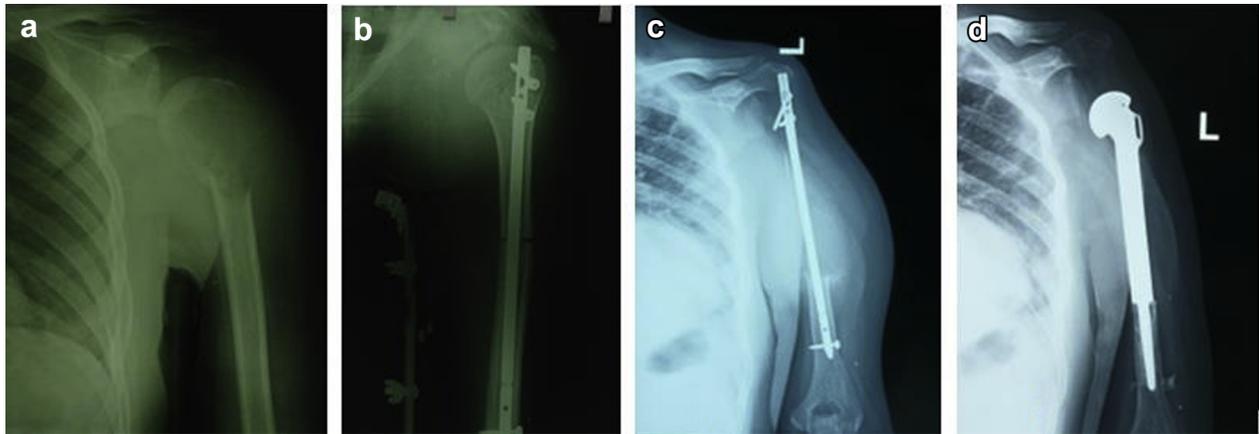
Left-sided Campanacci grade III proximal humerus giant cell tumor in a 22-year-old man (case 15 in [Table I](#)). (a, b) Pre-operative and postoperative radiographs are shown; the reconstruction used a large segmental osteoarticular allograft and intramedullary nail fixation. (c) A postoperative radiograph shows the recurrence with resorption of the osteoarticular allograft. (d) A postoperative radiograph shows the endoprosthesis used for revision. L, left.
